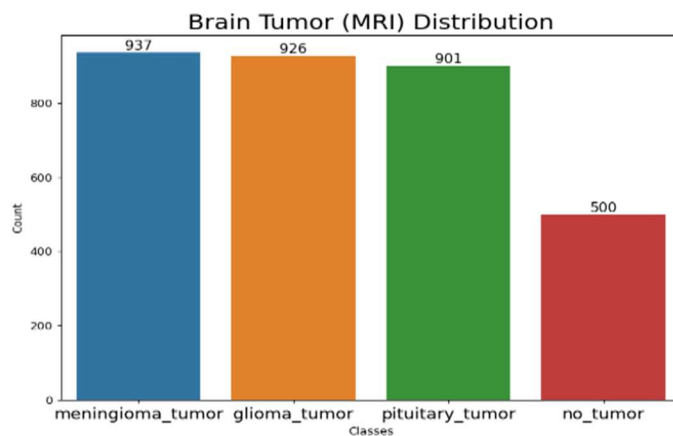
Count Plot for Brain Tumour (MRI) Distribution
